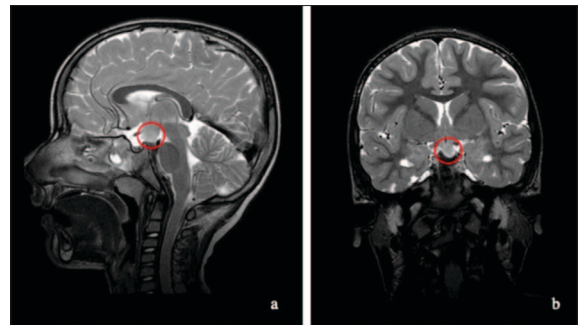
Cerebral MRI reveals a well-defined expansive mass in the interpeduncular cistern, measuring 14.5 × 13 × 12.5 mm, consistent with a sessile hamartoma of the tuber cinereum. The lesion displays a heterogeneous T2 signal, depicted in axial (Fig. 2a) and coronal (Fig. 2b) views.
